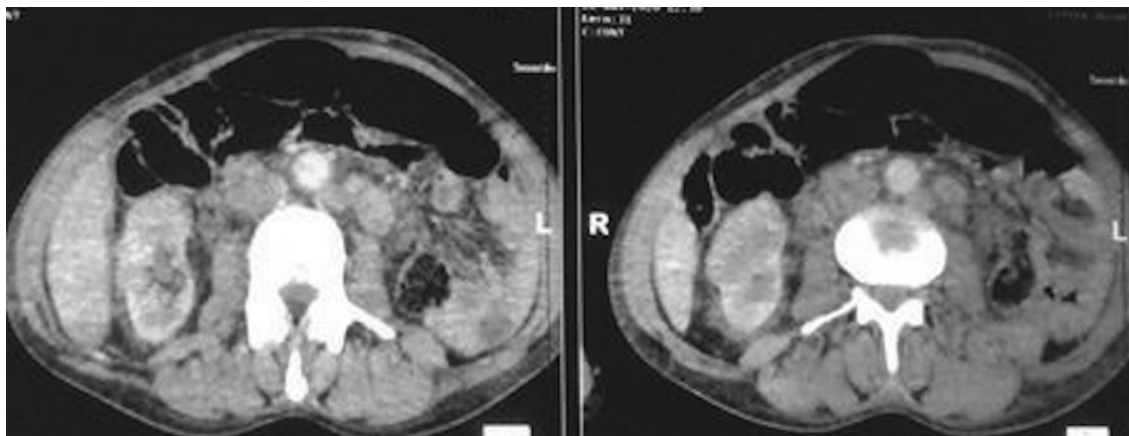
Abdominal CT scan with injection of contrast product showing a right polar renal lesion of heterogeneous density very suspicious of malignancy
